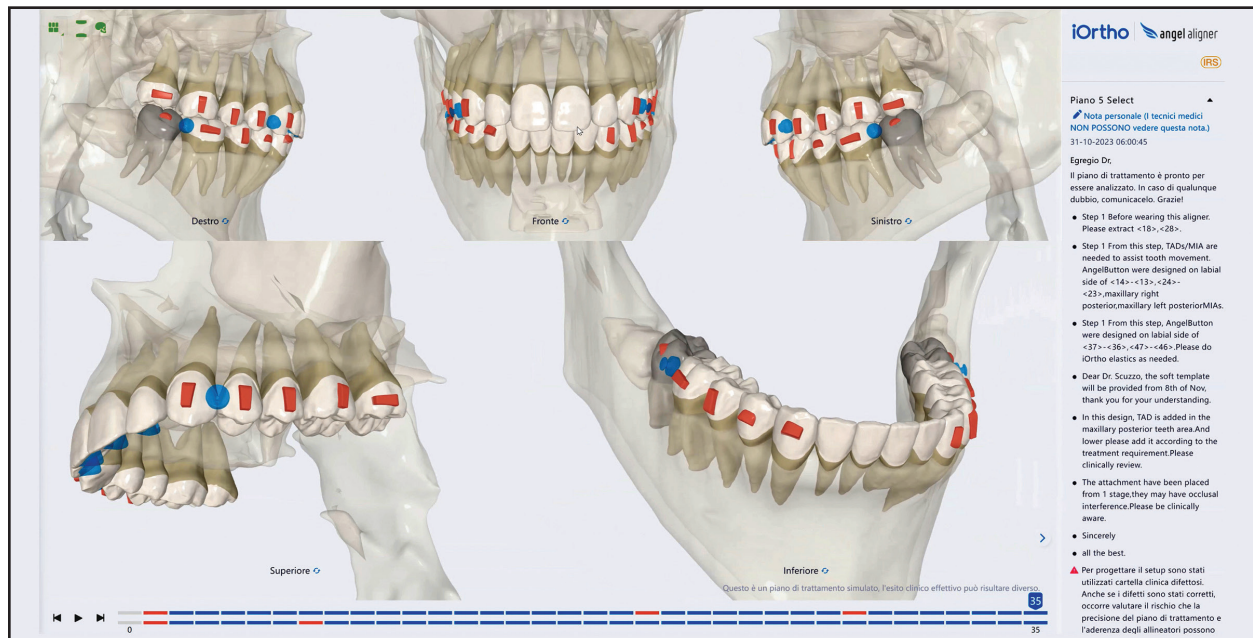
Integration of CBCT data for visualization of crowns, roots, and surrounding bone structures.
